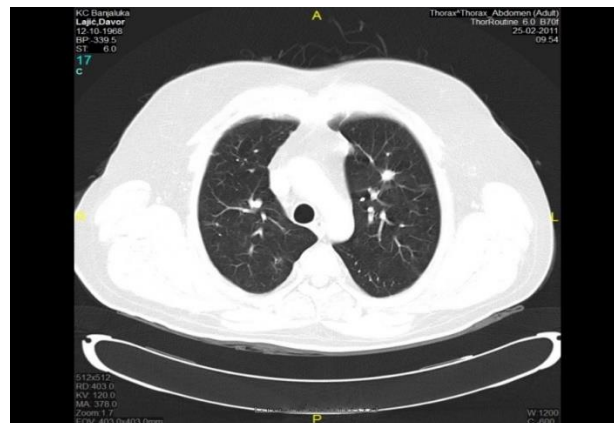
CT scan - regression of pulmonary metastasis.
